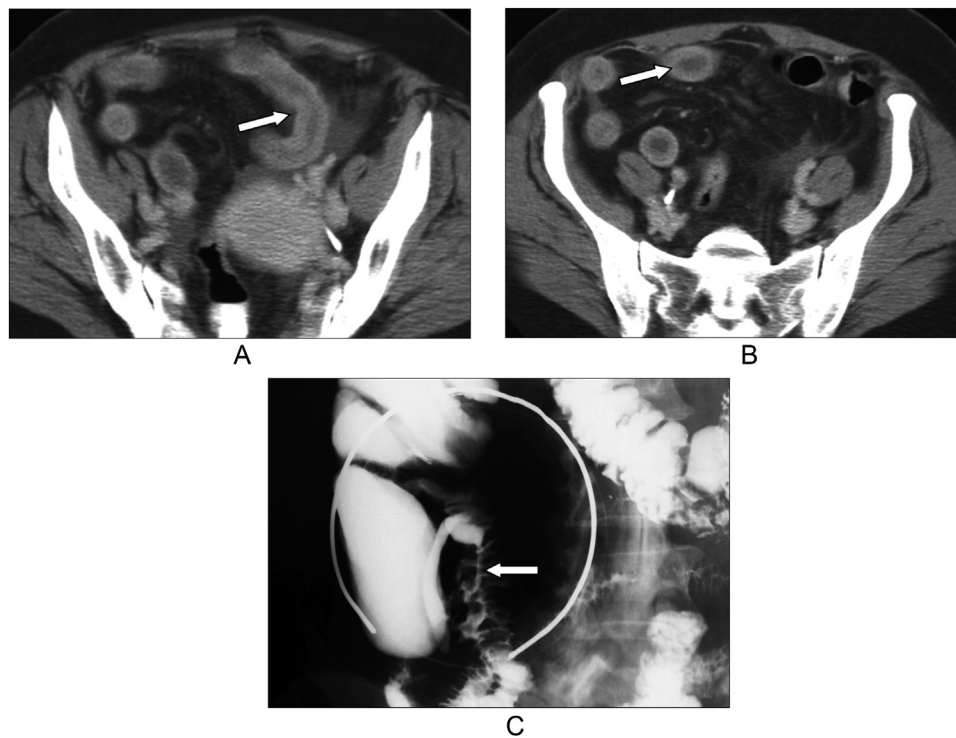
Eighty-three year-old woman with history of diarrhea, vomiting and diverticulosis. (A, B) Axial contrast-enhanced CT images show ascites, mild bowel wall thickening and mucosal enhancement of small bowel loops (arrow), also seen as nodular thickening of the terminal ileum on barium small bowel exam (arrow; C).
